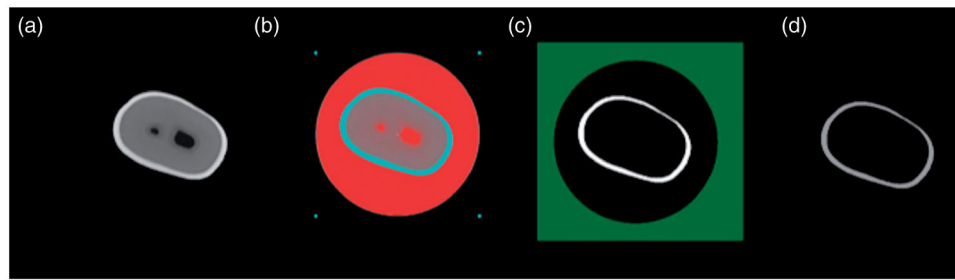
Micro CT images showing (a) axial image of tooth, (b) ROI selection on images, (c) thresholding and (d) binarization of the image by the grey-level histogram.
